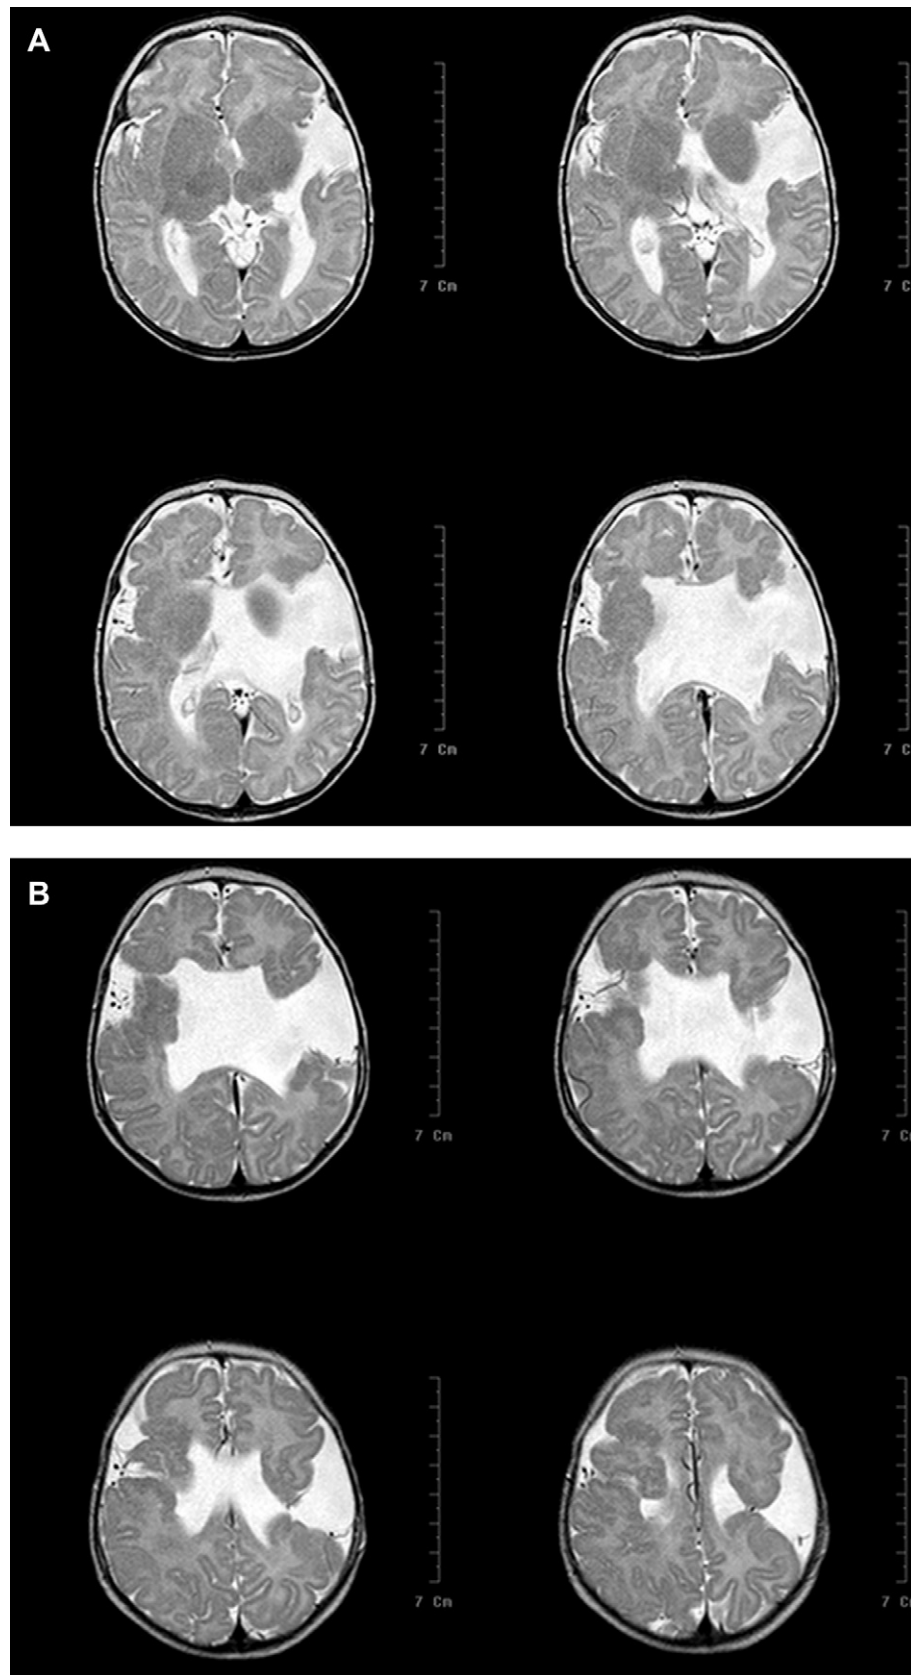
Postnatal magnetic resonance imaging revealed bilateral schizencephaly, right closed lip and left open lip (transverse view, T2-weighted image). (A) Main part of the left-side lesion. (B) Main part of the right-side lesion.
